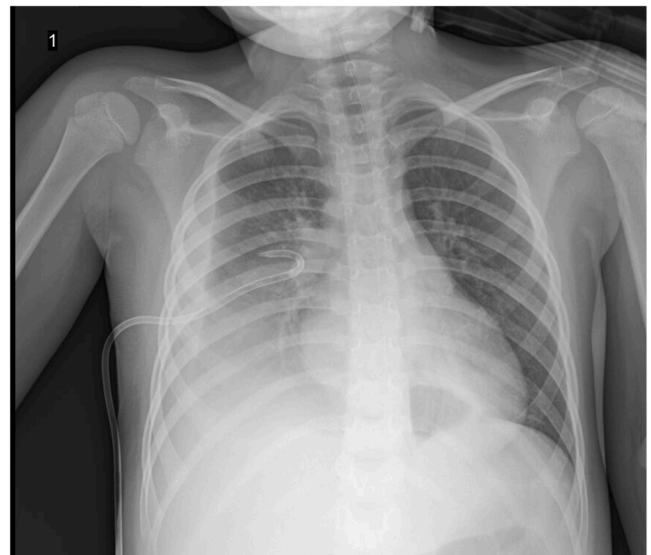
Anteroposterior chest X-ray showed chest tube and extensive right-sided lower lobe consolidation associated with pleural effusion.
